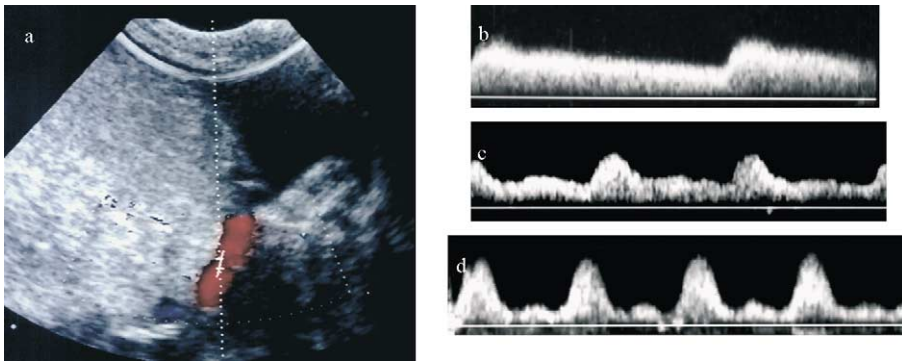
Marginal aspect of testicular artery: (a) Color Doppler ultrasound image (b) monophasic non-resistive waveform (c) biphasic, non-resistive waveform; and (d) biphasic, resistive waveform.
